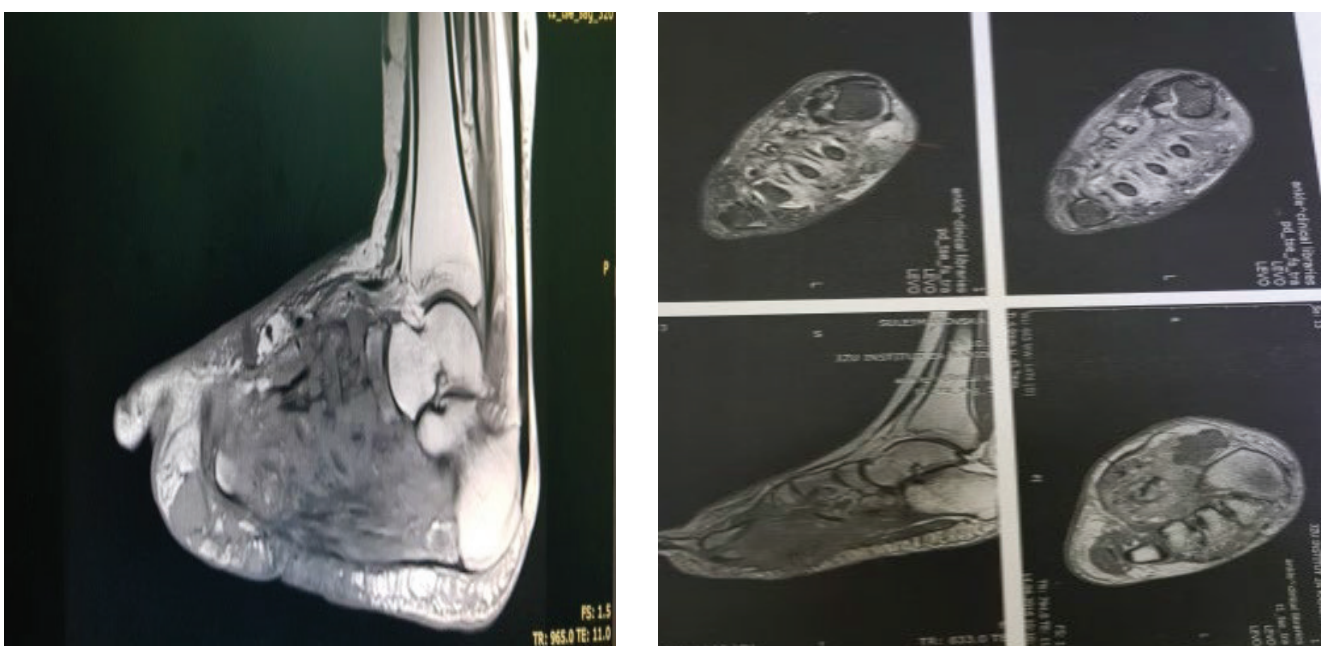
MRI of the left foot – DOT SIGNS
